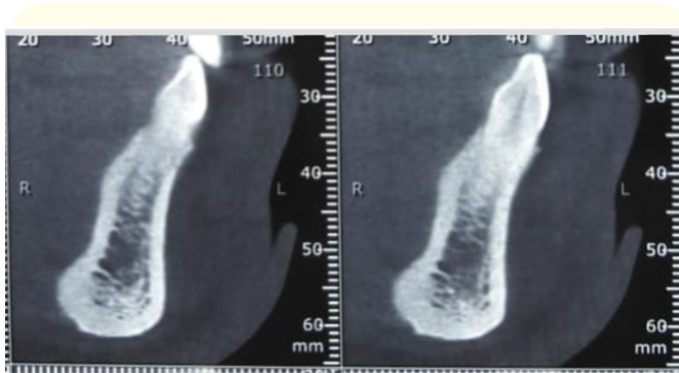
CBCT scan of the symphyseal area.
